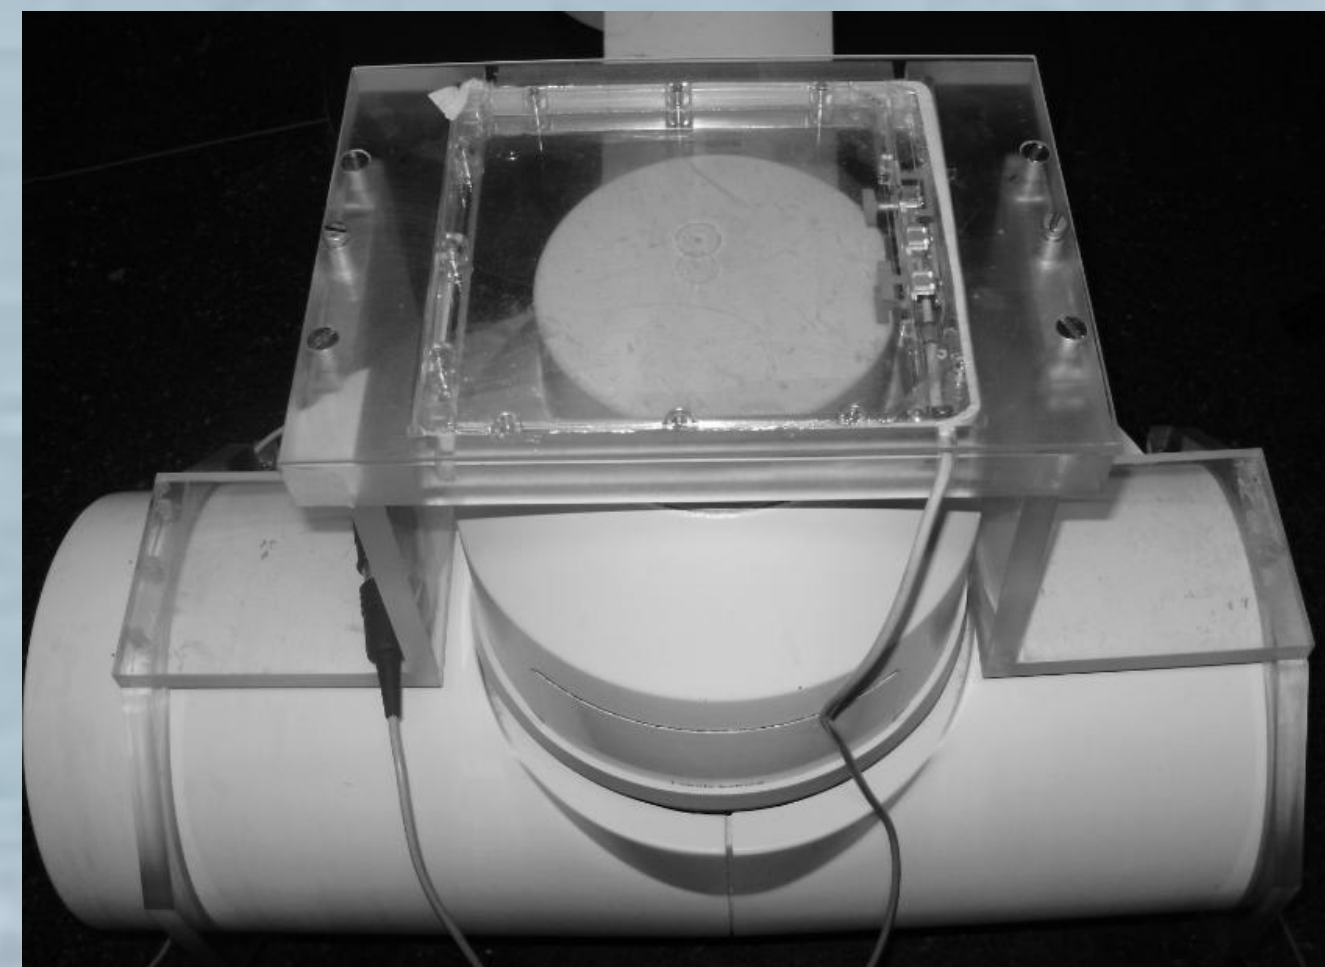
Supports for coupling the chamber to the output of X-ray tube
